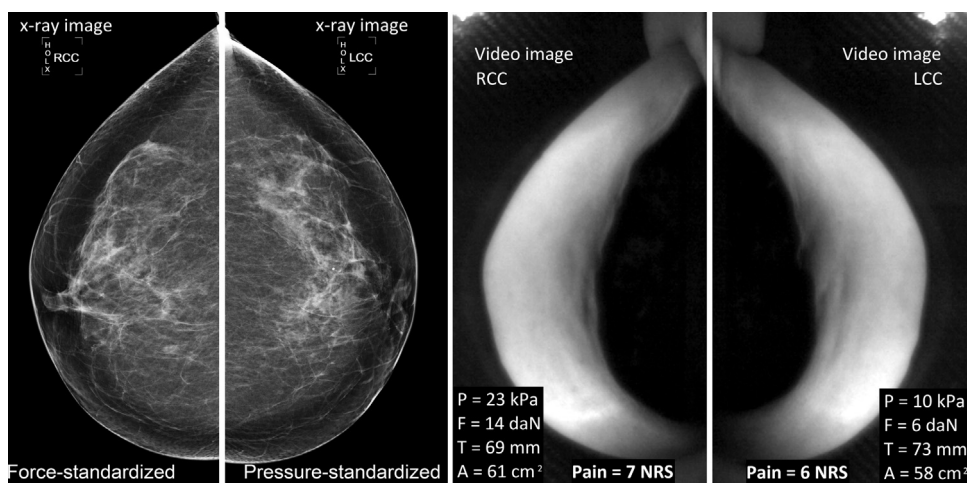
Example of over-compression: Left panels: X-ray images show no observable differences despite 8 daN higher force in the force-standardized compression (RCC). Right panels: corresponding visual images of the compressed breast (from video-camera positioned above the paddle). The contact area (shadow area on the breast) is similar for the left and right breast.
